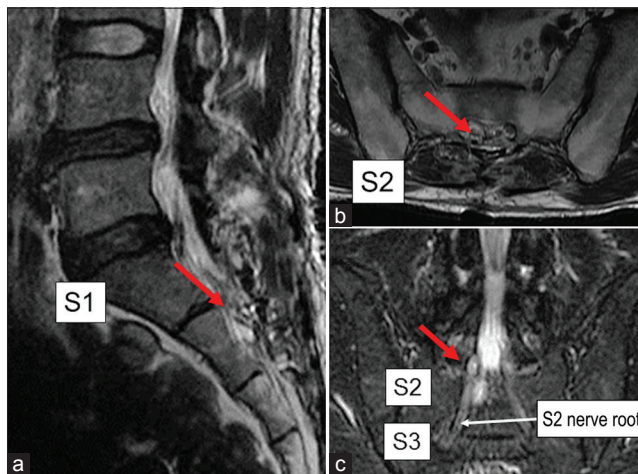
Postoperative magnetic resonance imaging. Postoperative magnetic resonance imaging showed a reduction in cyst size (red arrow) (a and b). There was no compression of the S2 nerve root (c)
